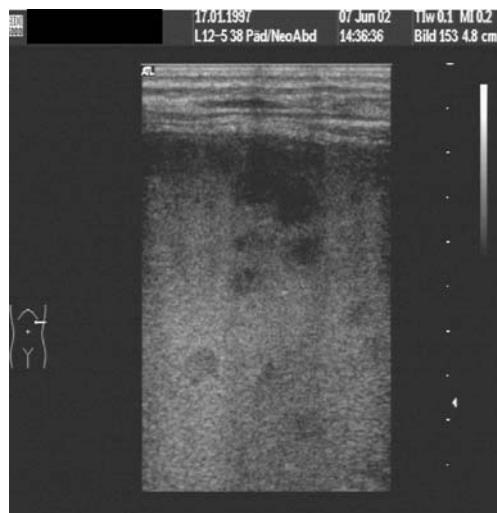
Ultrasound picture of the spleen in patient 1 showing hypoechoic lesions. *Candida albicans* was isolated via fine-needle puncture
